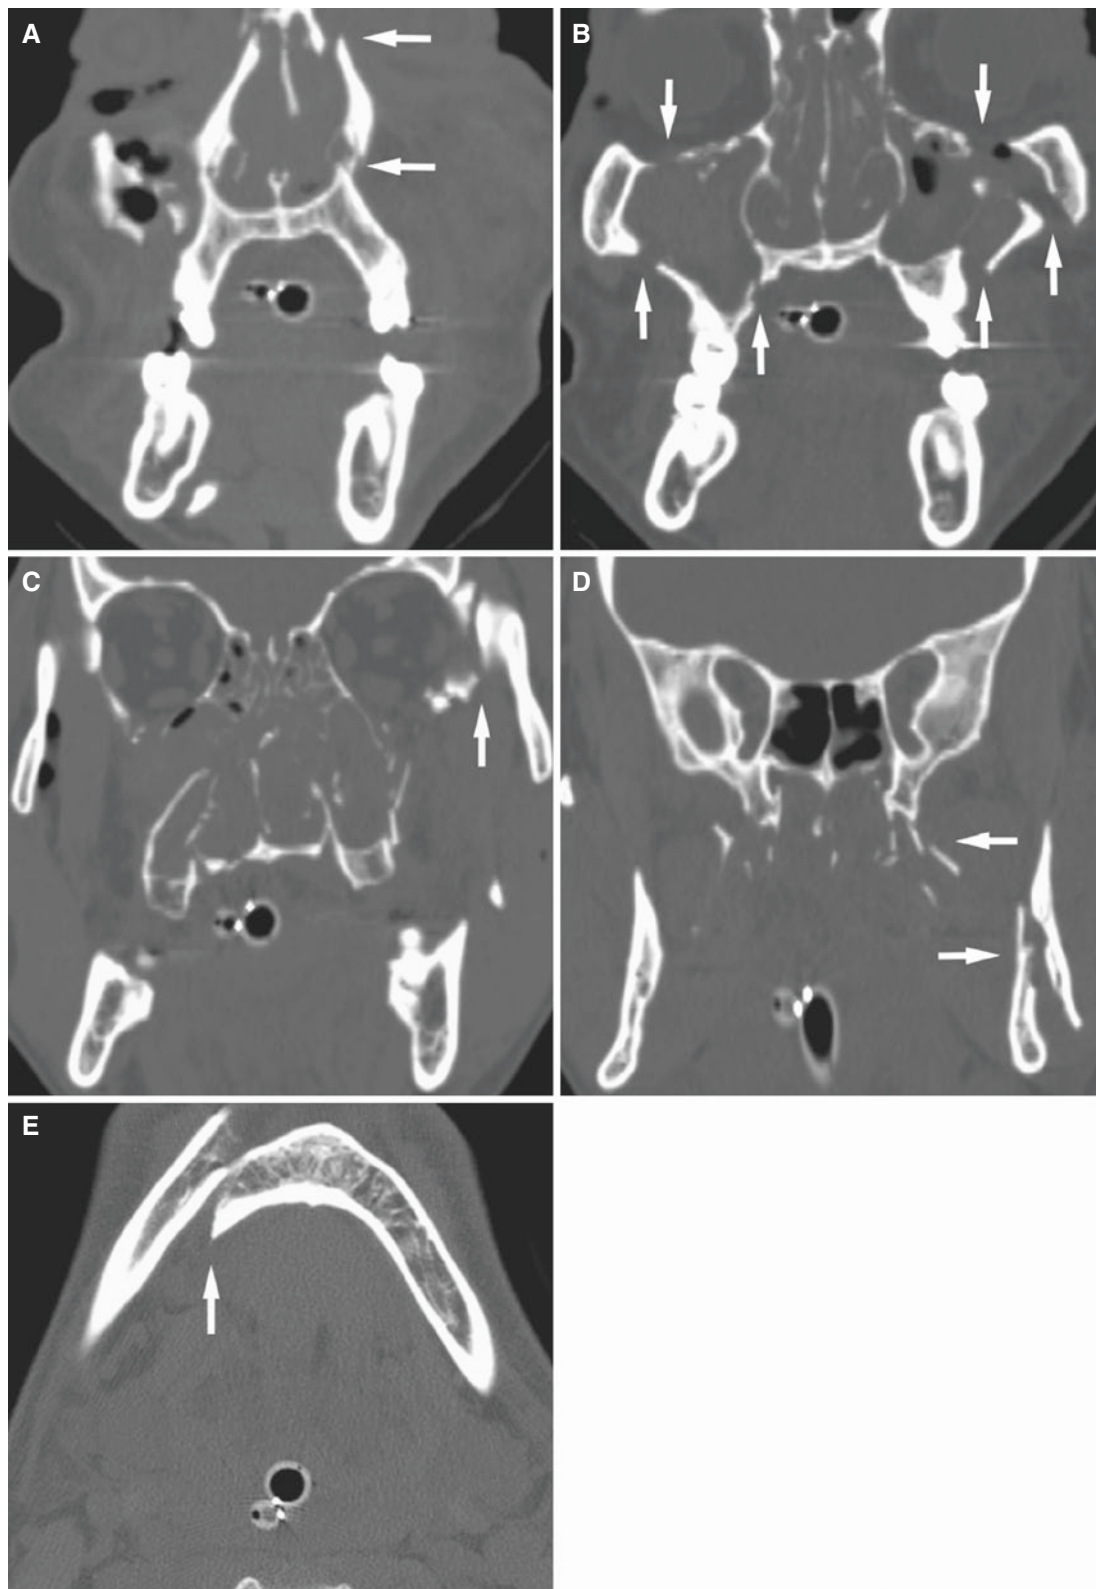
LeFort 3 and mandibular body fractures; 45-year-old male after motor vehicle crash with trauma to the face and head and loss of consciousness. (A) Coronal CT image shows bilateral fractures of superior nasal aperture near the nasal bone and inferior nasal aperture above the palate (*arrows*), opacification due to hemorrhage of the nasal cavity, bone fragments and air collections in the right cheek, and intratracheal tube. (B) Coronal CT image shows bilateral fractures of orbital floor
